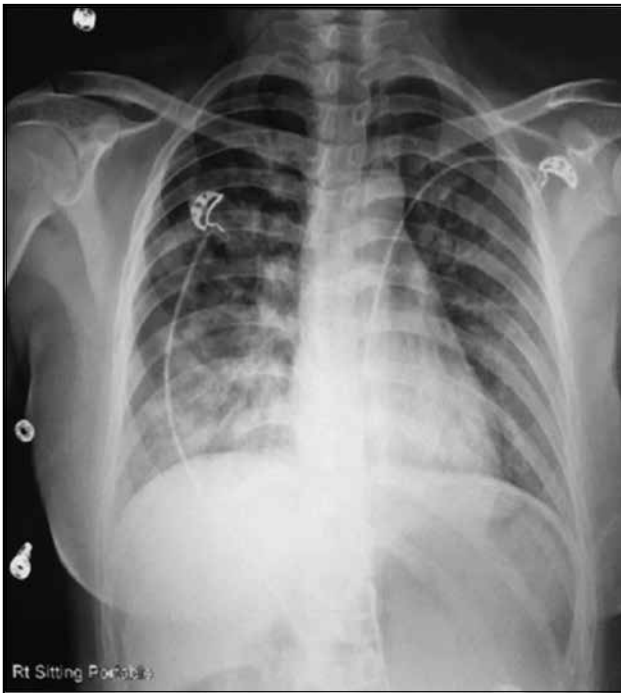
Chest radiograph showing bilateral diffuse haziness suggestive of acute respiratory distress syndrome.
